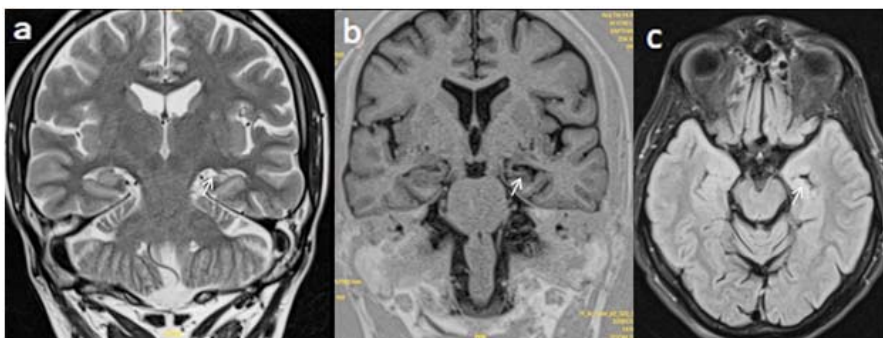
(a) T2 coronal, (b) T1 inversion recovery oblique coronal, (c) FLAIR showing loss of striations on the left side with loss of volume in left hippocampus
